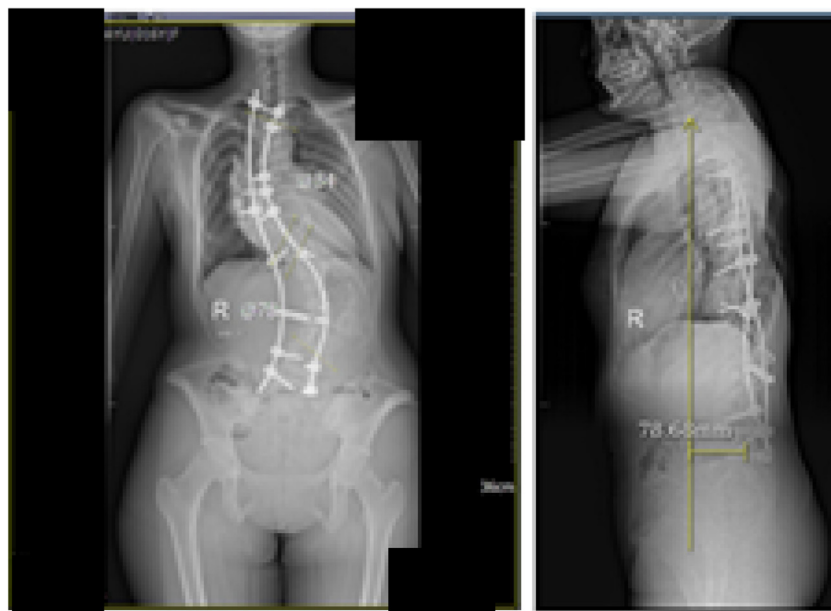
Postoperative Radiographic Examination.
